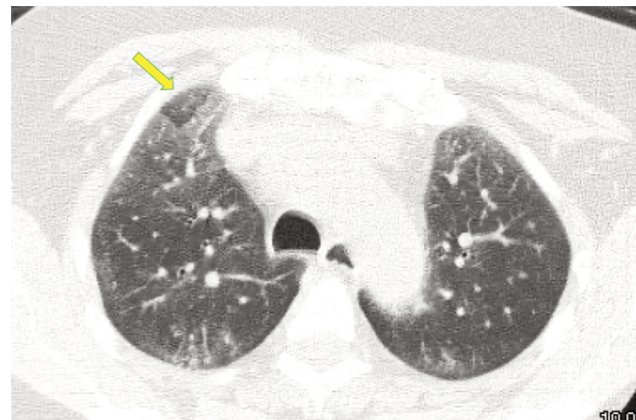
Prone expiratory HRCT image at presentation in a patient with SSc-ILD. Image demonstrates no significant air trapping (diffuse and bilateral involving three or more lobes). Mild lobular air trapping (arrow) is seen in the anterior right upper lobe. This patient was imaged in the prone position and the anterior lungs are dependent. Isolated lobular air trapping in dependent portions of the lung is common and should be considered physiologic and not indicative of significant small airways disease.
